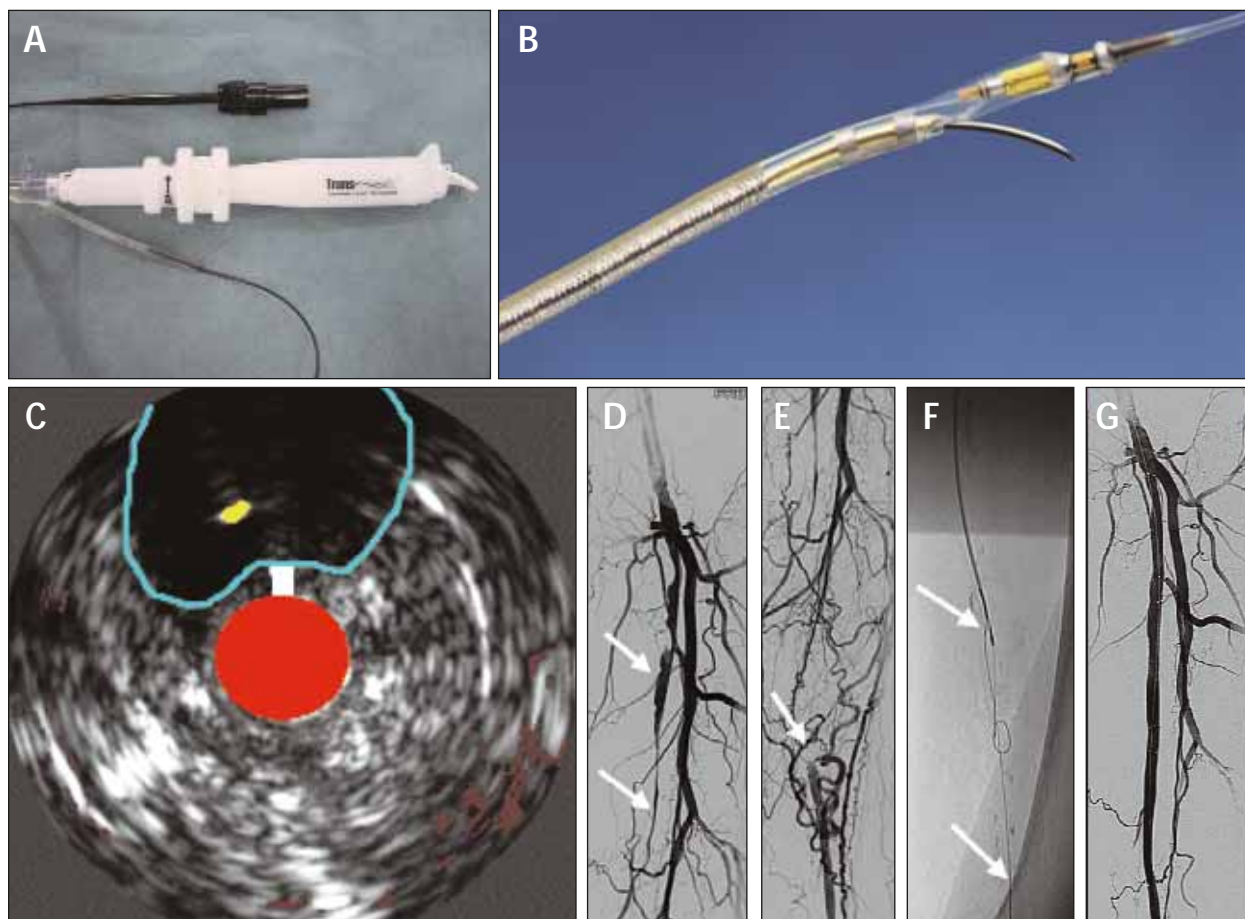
Example of the Pioneer re-entry catheter. Handle of Pioneer catheter with variable depth nitinol needle for re-entry (A, B). Ultrasound image with catheter oriented toward the true lumen at 12-o'clock position (C). Occluded left SFA (D). Distal reconstitution of SFA at the adductor canal (E). Image of the Pioneer catheter and successful re-entry into the true lumen (F). Final angiographic result (G).
